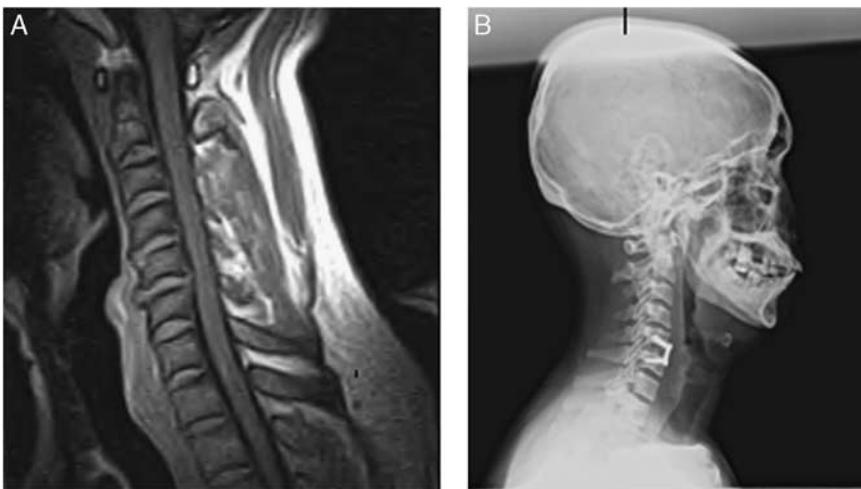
A and B, C5–C6 anterior cervical decompression and fusion (ACDF) done in the ambulatory surgery center. A, Preoperative magnetic resonance imaging (sagittal view). B, Two-week postoperative plain radiograph (lateral view).
